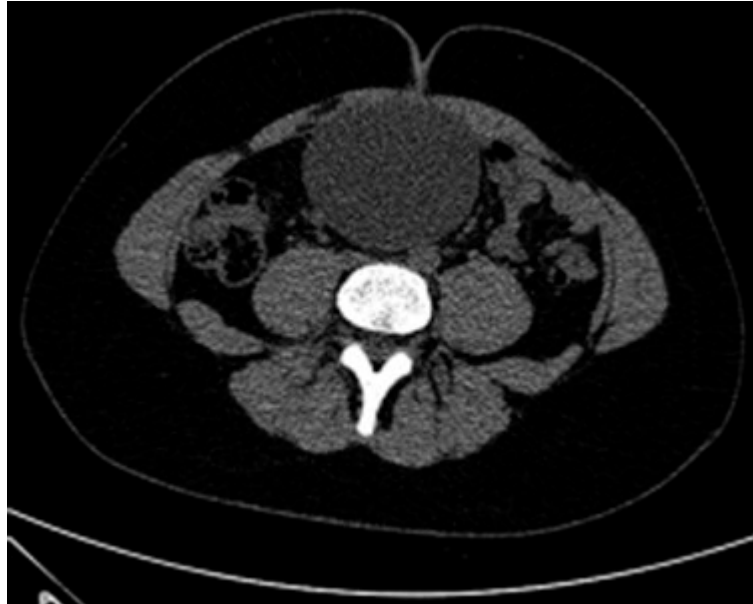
CT image of the mesenteric cyst.
